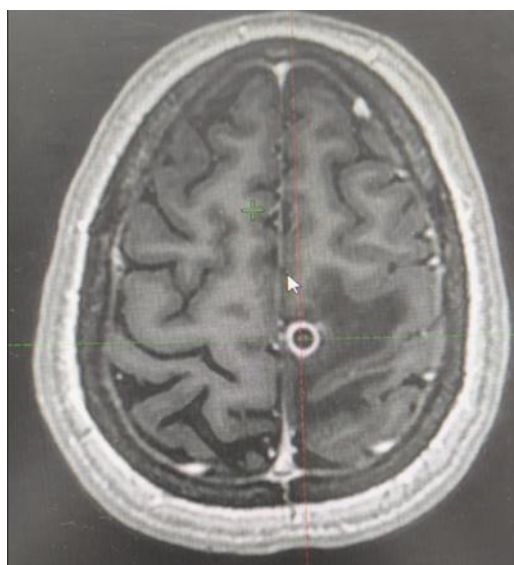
MRI brain showing calcified ring enhancing lesion suggestive of NCC.
